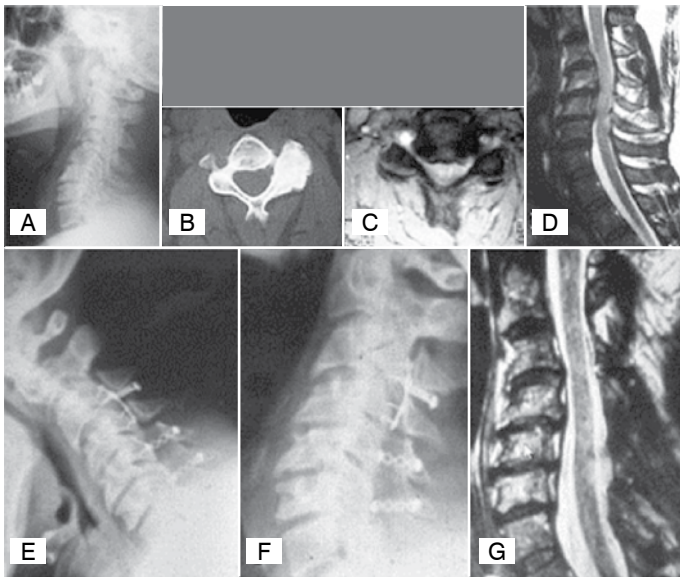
Patient age 56, driver wearing seat belt who had his vehicle rear-ended while stationary. Good initial response to treatment with corticoids and immobilization; however, in the annual follow-up visit he presents with deterioration of neurological state and undergoes surgery 18 months later with good functional outcome. A) Lateral radiography showing cervical spondyloarthritis; B) axial sections with facet joint impairment and osteophytes; C) MRI axial section showing spinal cord compression due to narrow cervical spinal canal; D) MRI midsagittal section showing spinal cord edema; E and F) Postoperative dynamic radiographies; G) MRI sagittal section one year after surgery showing correct spinal cord positioning.
